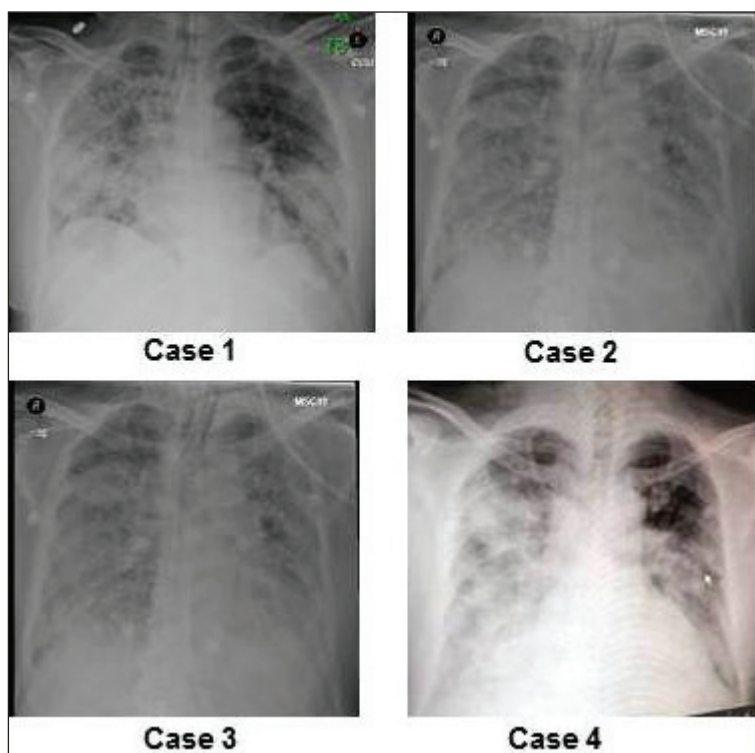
Chest x-ray of a patient showing bilateral lung infiltrates.
